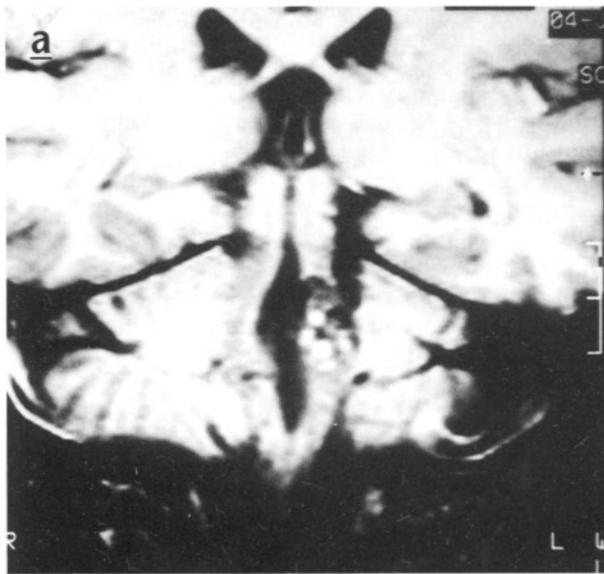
a, and b: T1-weighted MR images revealed the lesion characterized by a core of mixed signal intensity and a rim of decreased signal intensity. This appearance is highly characteristic for cavernous malformations. The linear signal void adjacent to the lesion outlines the venous structure.
